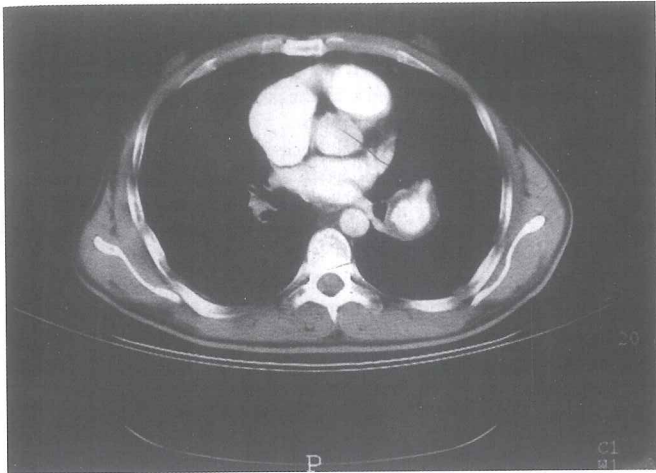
CT scan showing left thrombosed pulmonary artery aneurysm.
